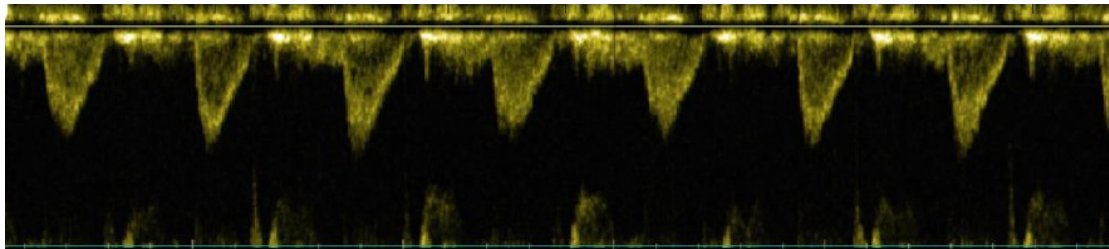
Image of a reconstructed Doppler Strip
